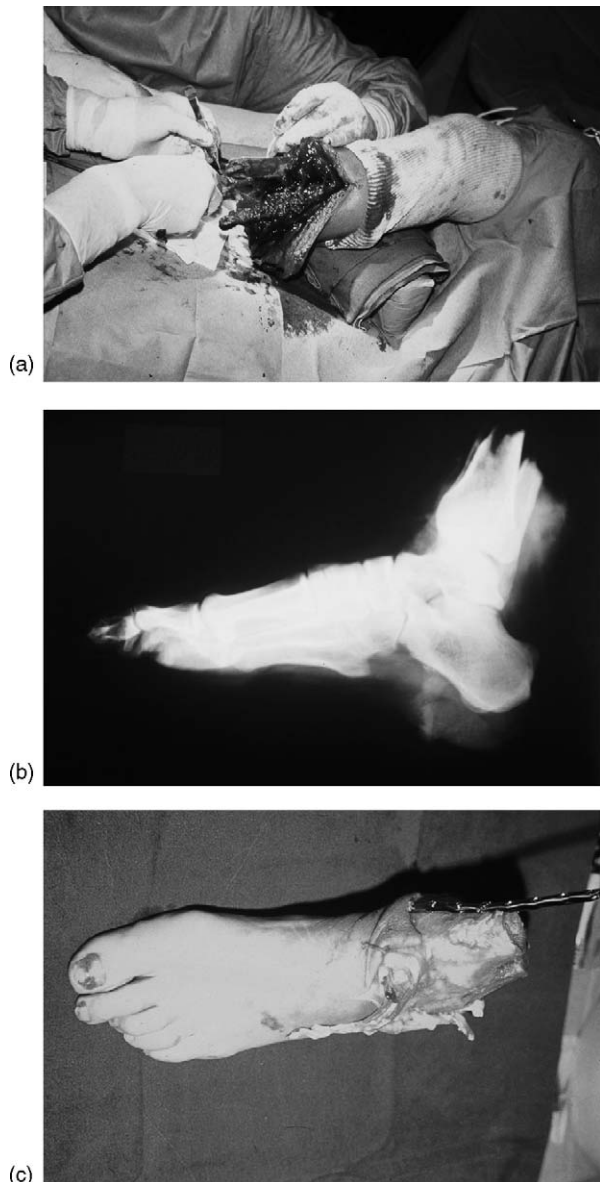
Traumatic amputation of the left leg of a 36-year-old woman (case 1). (a) Debridement of the multi-tissue lesions from the proximal end. (b) Preoperative radiograph of the amputated distal end. (c) Appearance of the distal end after debridement and insertion of the osteosynthetic plate.
